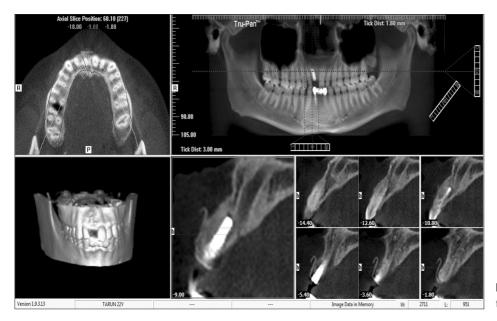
Computed tomography scan after 5 months.
